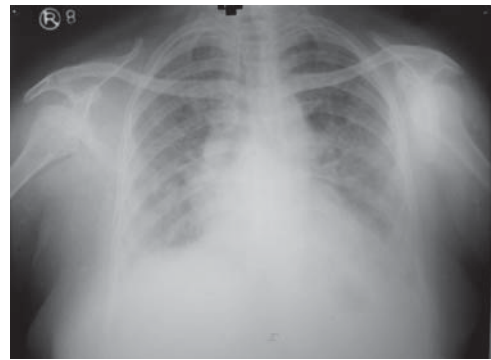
Chest x-ray revealed volume reduction and pulmonary fibrosis
